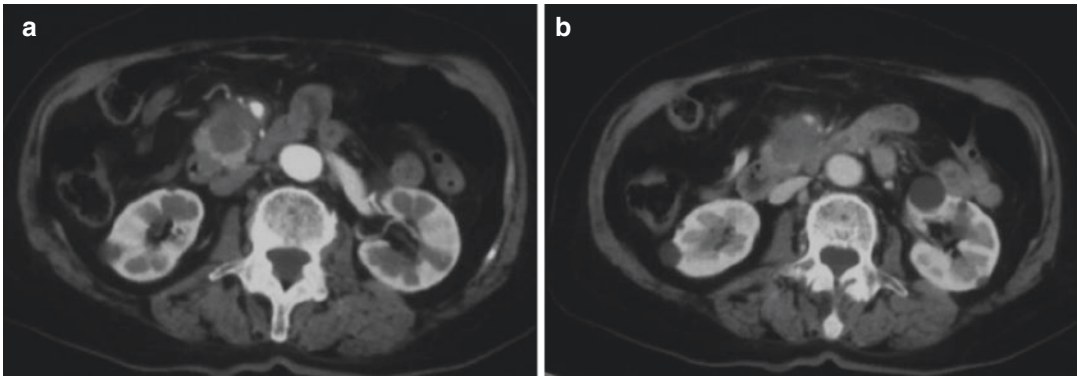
(a, b) CT image showed a mass in the uncinus process of the pancreas
